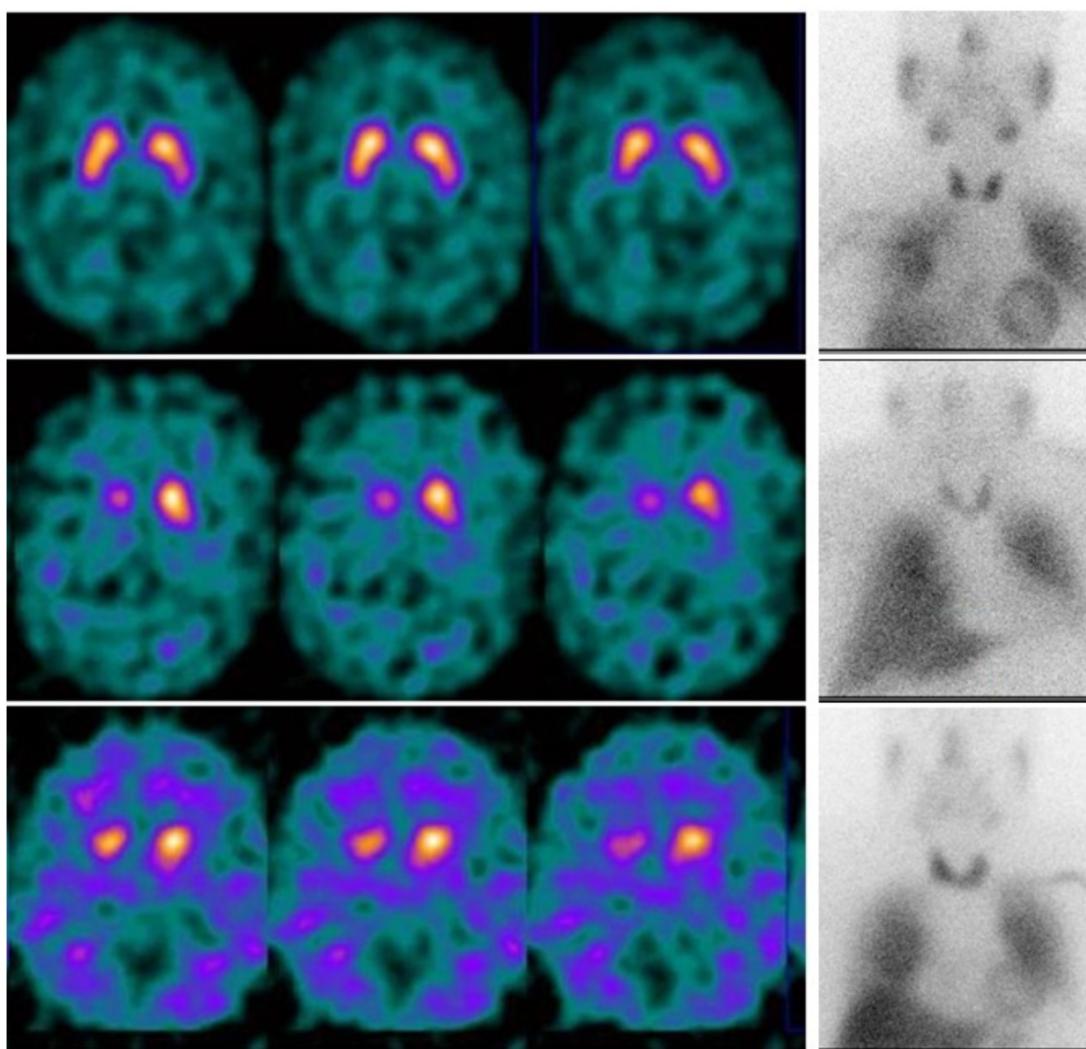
Combination of $[^{123}\text{I}]$ Ioflupane SPECT and $[^{123}\text{I}]$ MIBG scintigraphy in the study of parkinsonism. Top row: healthy patient: preserved uptake in both striatal nuclei and integrity of myocardial sympathetic function. Middle row: patient with PD: bilateral asymmetric striatal hypodensity and absence of myocardial sympathetic function. Bottom row: patient with MSA-P: bilateral striatal hypodensity (more symmetrical) with marked presence of cortical nonspecific activity and intact or slightly decreased myocardial sympathetic function.
